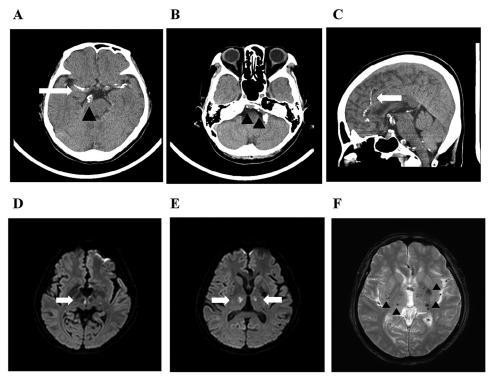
Brain computed tomography imaging. (A) Intracranial arterial calcifications of both middle cerebral artery (arrow) and basilar artery (arrowhead). (B) Intracranial arterial calcifications of the tortuous left vertebra artery (arrowheads). (C) Intracranial arterial calcifications of anterior cerebral artery (arrow); brain magnetic resonance imaging. (D) hyperintensity of right midbrain on diffusion-weighted imaging (arrow). (E) Hyperintensities of both thalami on diffusion-weighted imaging (arrows). (F) Multifocal hypointensities of both basal ganglia and thalami on gradient echo imaging (arrowheads).
